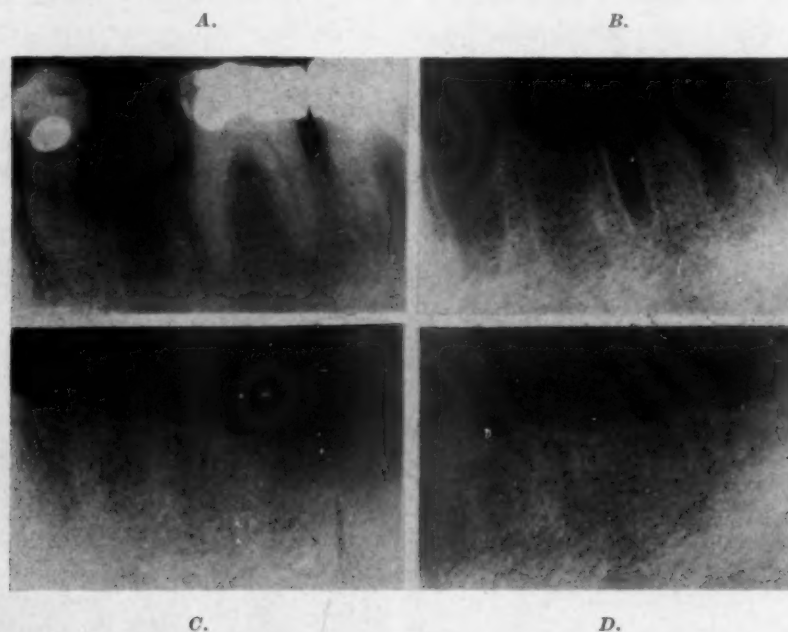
Roentgenograms before and after the extraction of lower left first premolar and first and second molars. *A*, Before extraction; *B*, One month after extraction; *C*, eighteen months after extraction; *D*, twenty-four months after extraction. Note remaining alveolar bone in *B* and absence in *C* and *D* with reorientation of supporting bone. (Pl. 1834, 1833, 1832, 1831.)
